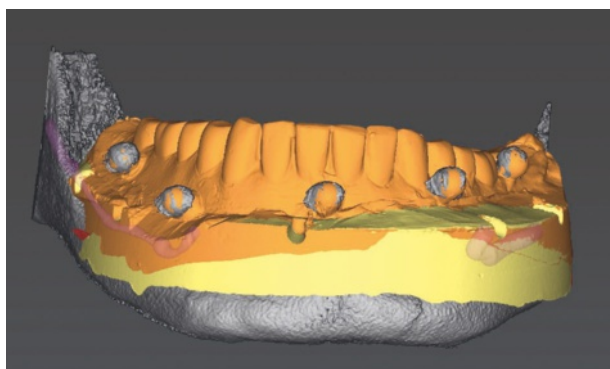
The measuring sphere is used to match the CBCT with the denture-on-cast STL dataset.
